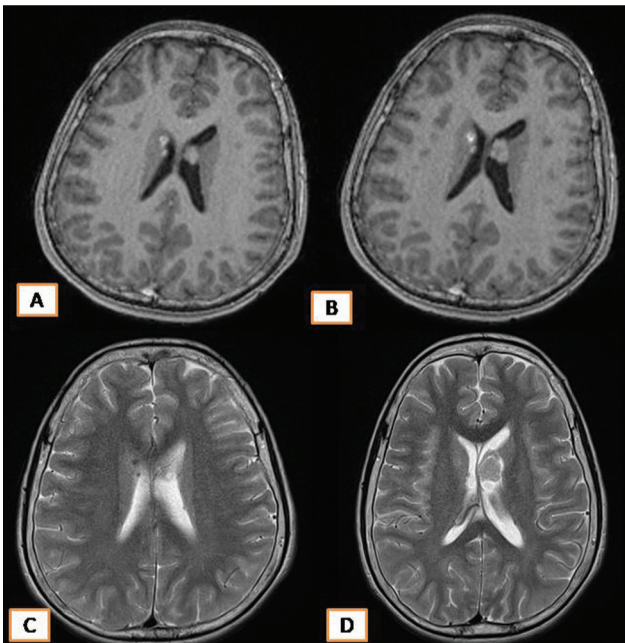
(A–D) Magnetic resonance imaging brain axial fluid-attenuated inversion recovery (FLAIR) and T2-weighted imaging. Note: A well-defined intraventricular T2 intermediate-to-low signal lesion noted in the body of left lateral ventricle. The lesion is incompletely suppressed on FLAIR. Multiple subependymal nodules are noted in bilateral lateral ventricles, which are T2 hypointense.
